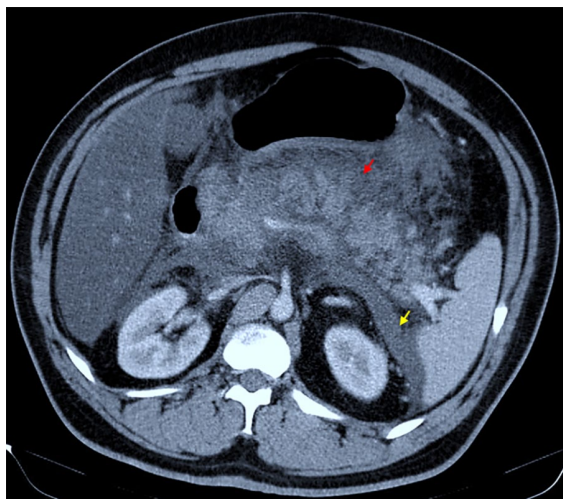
The abdominopelvic CT scan indicated the presence of acute pancreatitis, with observed swelling and edema surrounding the pancreas, as well as notable fat stranding (red arrow) and ascites (yellow arrow).
